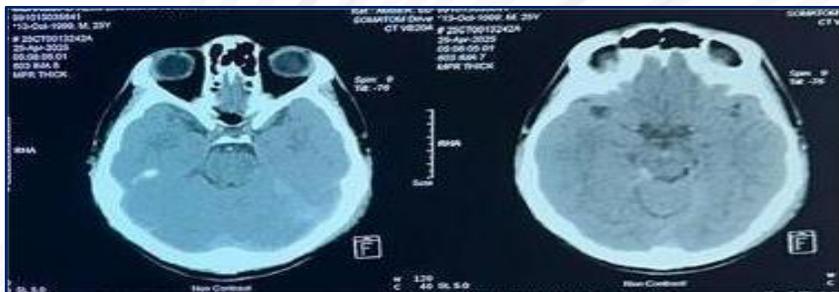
CT brain revealed an acute subarachnoid hemorrhage seen in ambient cistern and interpeduncular cistern with acute subdural hemorrhage along the left tentorium cerebelli and posterior falx
